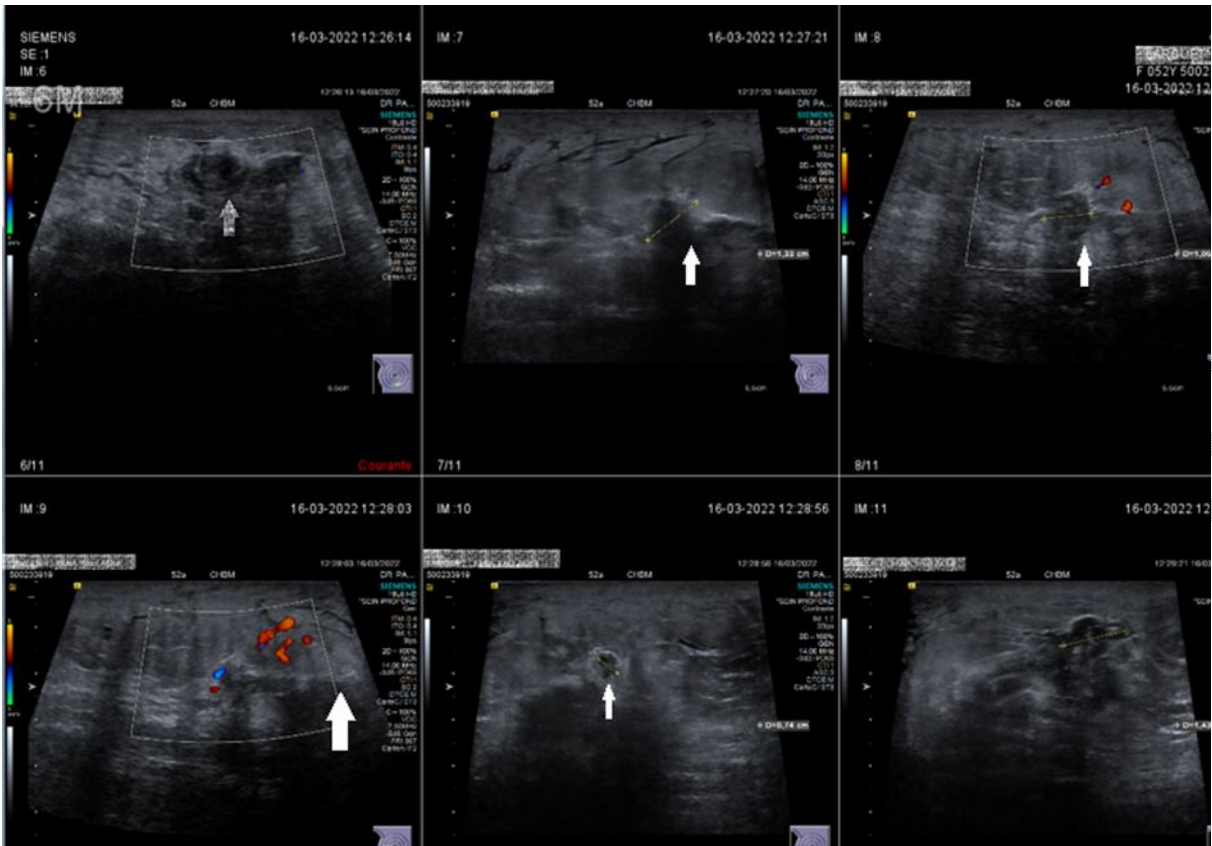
A breast ultrasound found a nodule of the breast with a malignant aspect and vascularized on echodoppler (arrow) .
